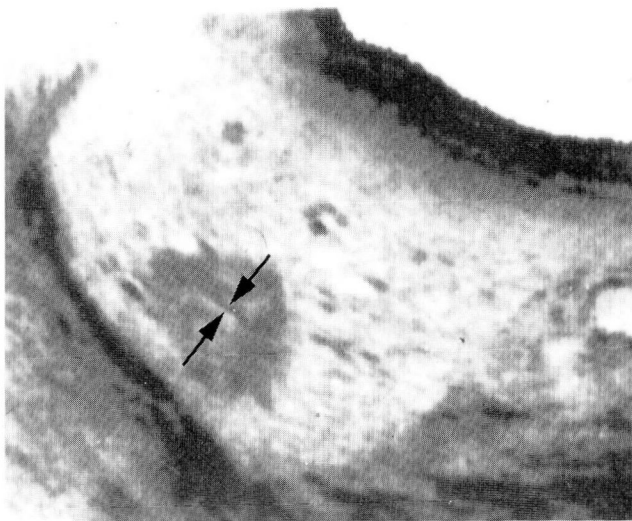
Longitudinal ultrasound of the right lobe of the liver in a different patient. A well-circumscribed echogenic mass with a septum in its central portion is seen (*arrows*). Combination of these findings is diagnostic of a cavernous hemangioma. No further examinations were required in this asymptomatic patient.
